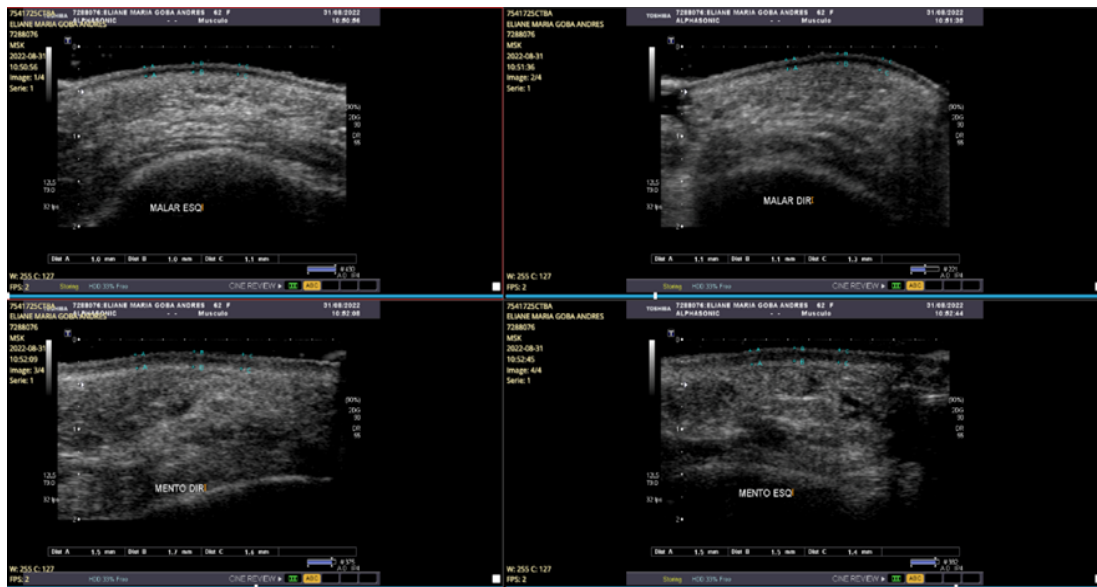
Right and left malar and mentonian evaluation by ultrasound imaging before oral and topical silicon in OR group.
